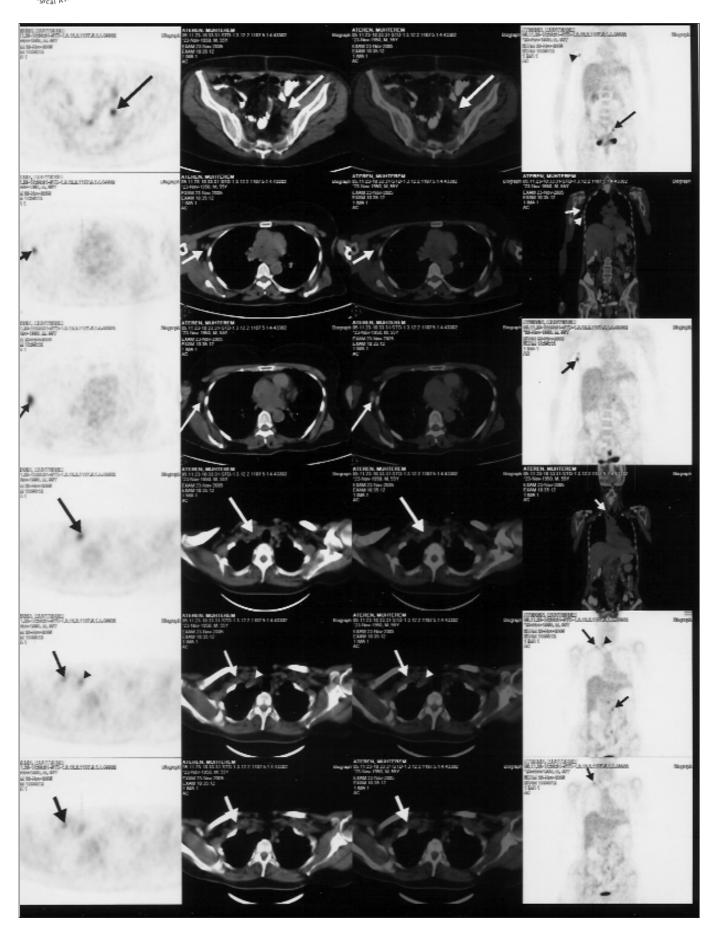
The requested PET investigation revealed pelvic and para-aortic hypermetabolic involvement, right axillary (SUV $_{max}$: 5.7) and supraclavicular LAM (SUV $_{max}$: 5.1).
